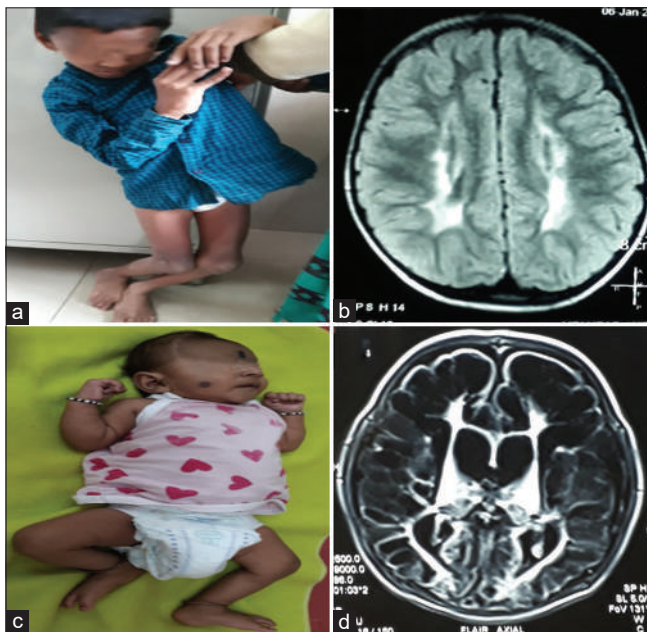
(a) Bilateral spastic cerebral palsy – spastic diplegic type with scissoring of both lower limbs with deformity. (b) Magnetic resonance imaging (MRI) of brain T2 axial sections showing periventricular hyperintensities suggestive of periventricular leukomalacia. (c) Clinical photo showing microcephaly in a child with bilateral spastic cerebral palsy of quadriplegic type with multicystic encephalomalacia with subdural effusion on MRI of brain (d).
